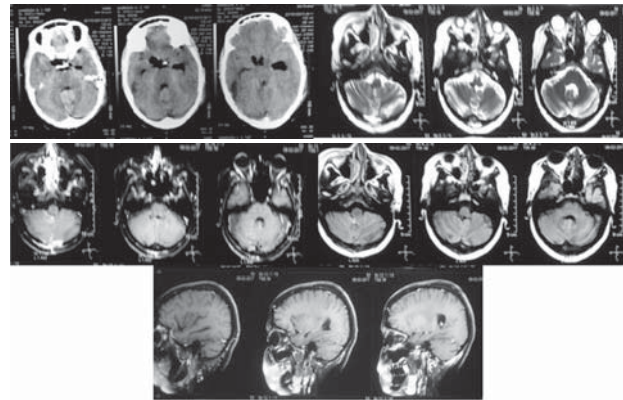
Post-Operative:-CT and MRI reports showed no residual tumour and resolving hematoma.
